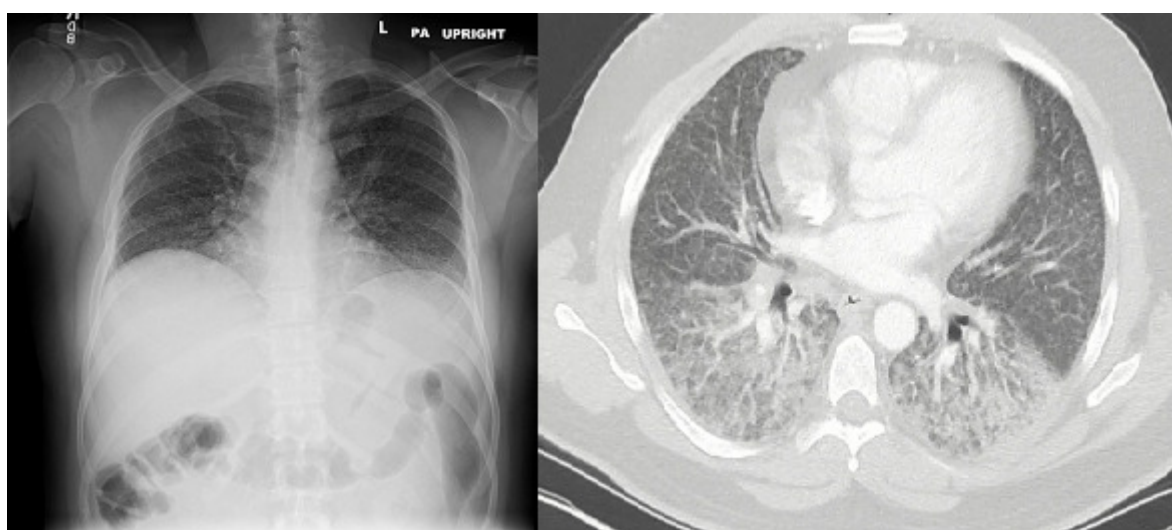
Plain radiograph of the chest (left panel) revealing bilateral interstitial opacities and computed tomography (CT) of the chest (right panel) revealing bilateral basal ground glass opacities.
